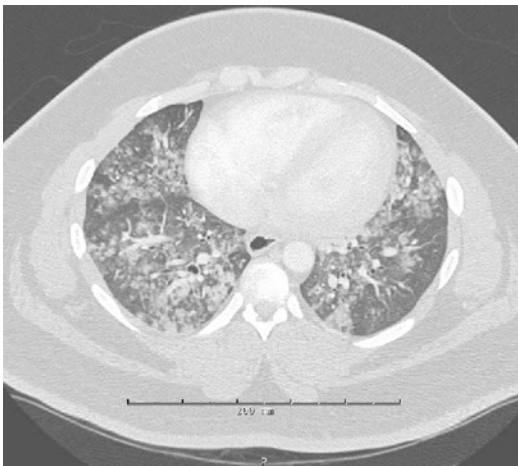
CT chest of a patient with ARDS showing diffuse extensive bilateral focal alveolar airspace opacities
